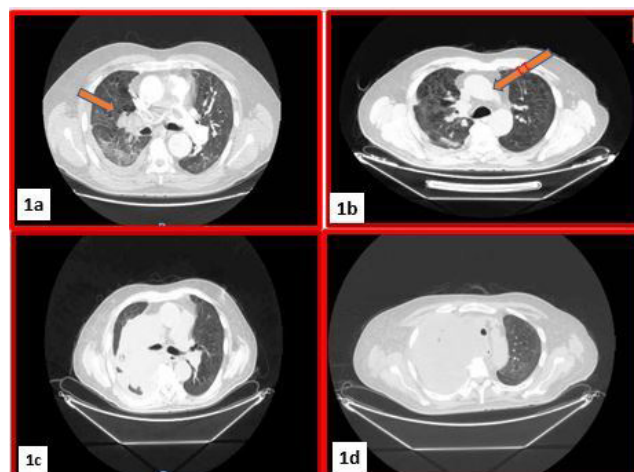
(a) "CT Scan (05/08/2023) - Extensive endoluminal filling defect affecting the common trunk, and extends to extensively affect the right Pulmonary Artery (arrow); (b) CT Scan (05/19/2023) - In the right perihilar site, mostly represented at the level of the upper lung sector, solid tissue with lobulated margins (arrow) Endoluminal filling defects with an occlusive-subocclusive appearance affecting the right PA branches, the PA common trunk; (c) CT Scan (08/21/2023) - Compared to the previous CT check, the already known solid tissue appears increased, occupying a good part of the right lung field; (d) CT Scan (08/28/2023) - Further increase in the predominantly hypodense non-homogeneous solid tissue that occupies almost the entire right lung area.
